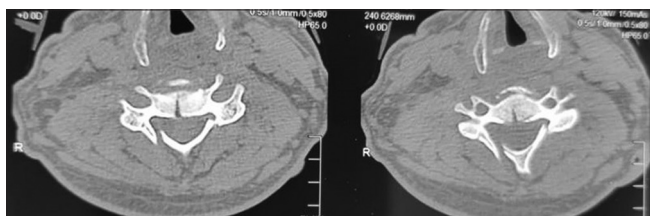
Computed tomographic scan axial view of cervical spine demonstrating facet fracture in addition to C5 body fracture
